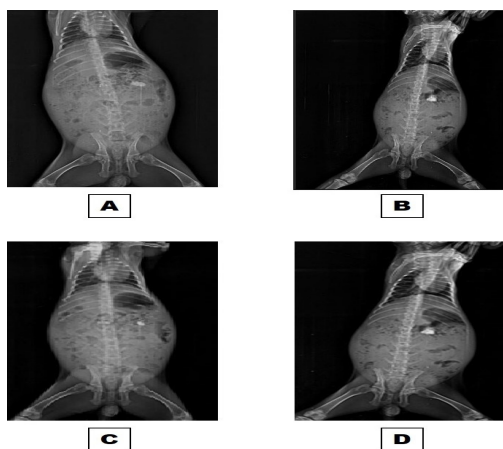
X-ray images A, B, C and D, taken at time intervals of 2, 4, 8 and 12 hours, respectively
